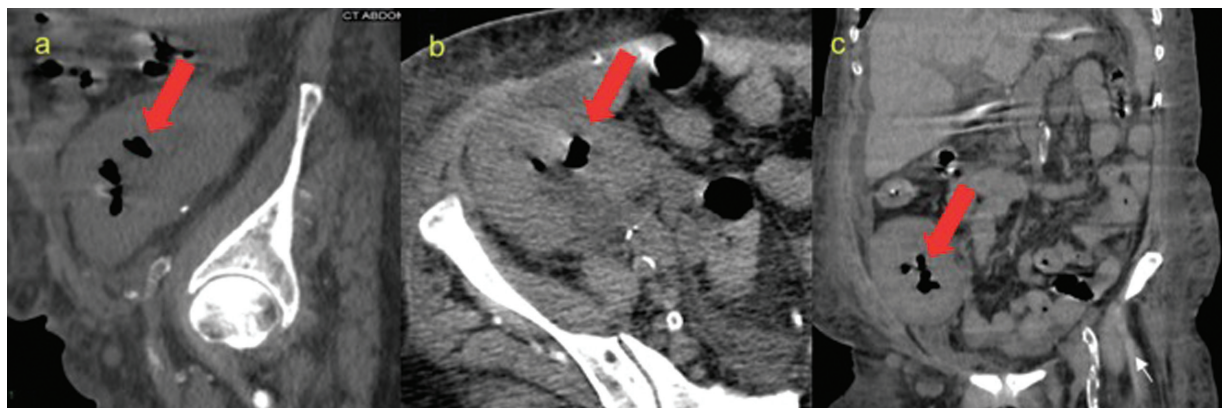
Plain CT images in sagittal (a), axial (b), and coronal (c) planes show a transplanted kidney in RIF. Few air foci (red arrows) were noted within the pelvicalyceal system of the transplanted kidney suggesting emphysematous pyelonephritis. CT, computed tomography; RIF, renal interstitial fibrosis.
